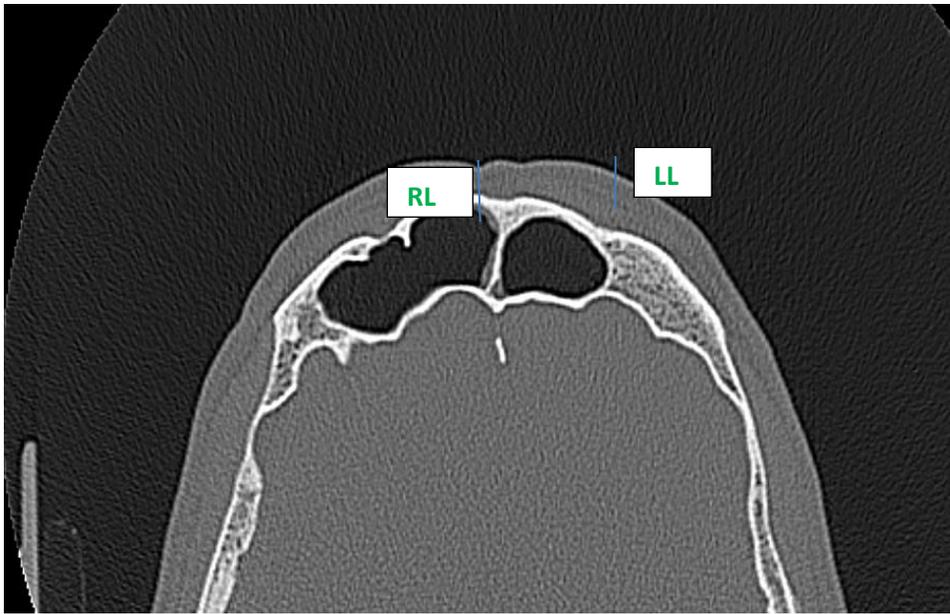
CT of male frontal sinuses (axial view) showing right sinus anteroposterior length (RL) and left sinus anteroposterior length (LL) “Quoted from work station”
